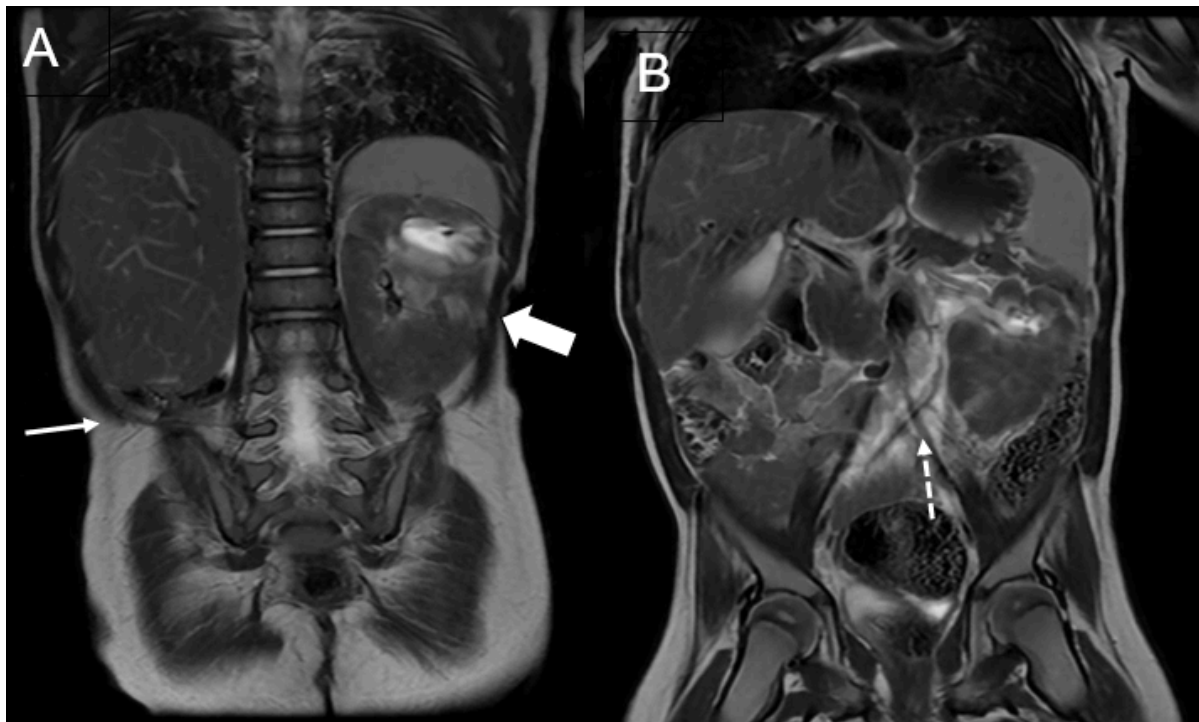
Coronal T2-weighted MRI image. (A) showing an empty right renal fossa (small white arrow). The left kidney is fused with the hydronephrotic ectopic right kidney, forming a single fused kidney (Thick white arrow). (B) shows the right ureter crossing the midline anterior (small dotted white arrow). to the left external iliac artery.
